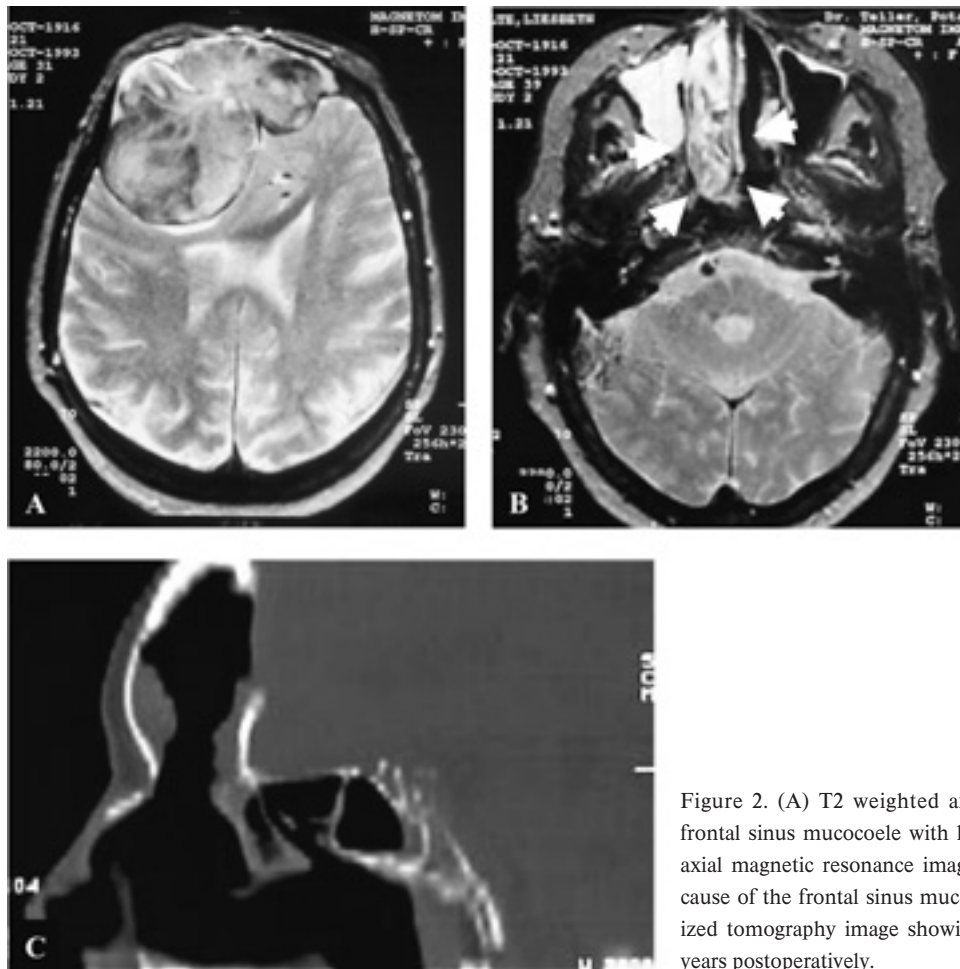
(A) T2 weighted axial magnetic resonance image showing a frontal sinus mucocoele with large intracranial extension. (B) T2 weighted axial magnetic resonance image showing an inverted papilloma to be the cause of the frontal sinus mucocoele. (C) Sagittal bony window computerized tomography image showing inconspicuous frontal sinus conditions 6 years postoperatively.
